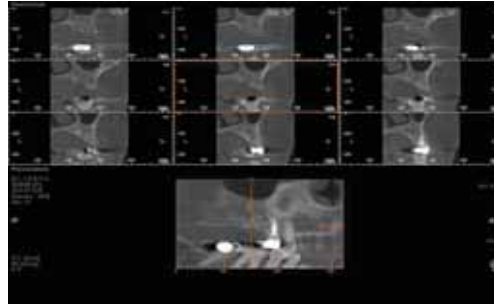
CT shows bone defect on palatal side.
